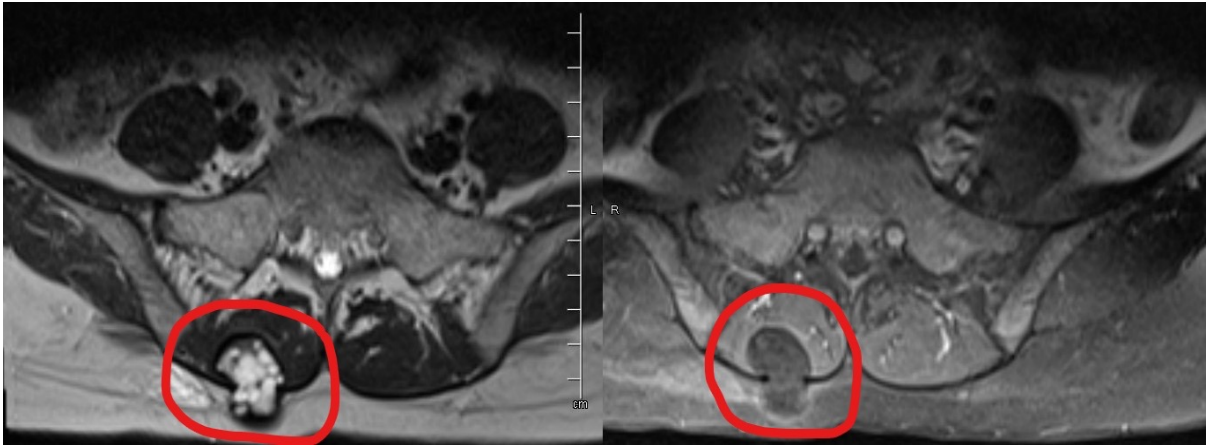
Pre-op period (area marked with red ring): Axial Lumbar MRI examination shows a lipomatous mass extending from the subcutaneous region in the lower right part of the sacrum to the paravertebral muscle. (Pathological evaluation: Hydatid Cyst)
